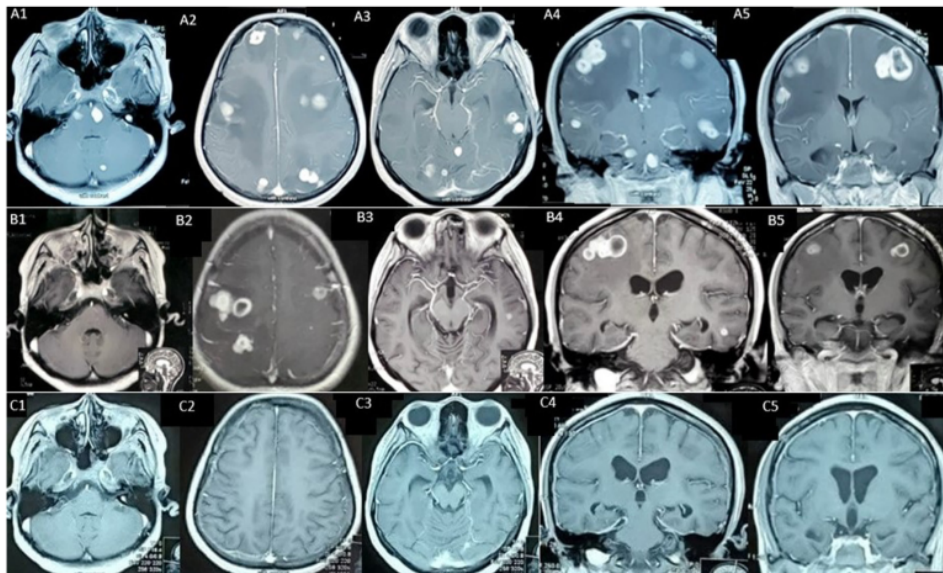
(A) A1-A5 initial head MRI with contrast showed multiple parenchymal cystic lesions with scolex. (B) B1-B5 head MRI with contrast after 6.5 months after initial treatment showed multiple parenchymal cystic lesions. (C) C1-C5 head MRI with contrast after 15 months of albendazole therapy showed almost diminished nodule.
